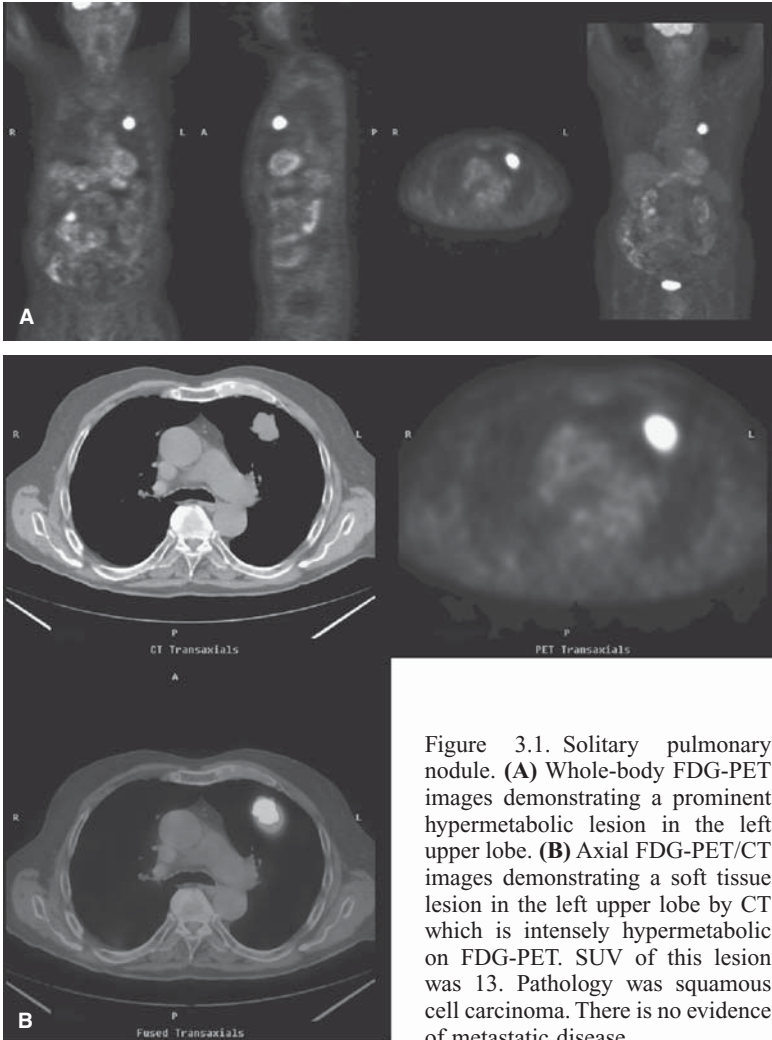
Solitary pulmonary nodule. (A) Whole-body FDG-PET images demonstrating a prominent hypermetabolic lesion in the left upper lobe. (B) Axial FDG-PET/CT images demonstrating a soft tissue lesion in the left upper lobe by CT which is intensely hypermetabolic on FDG-PET. SUV of this lesion was 13. Pathology was squamous cell carcinoma. There is no evidence of metastatic disease.
